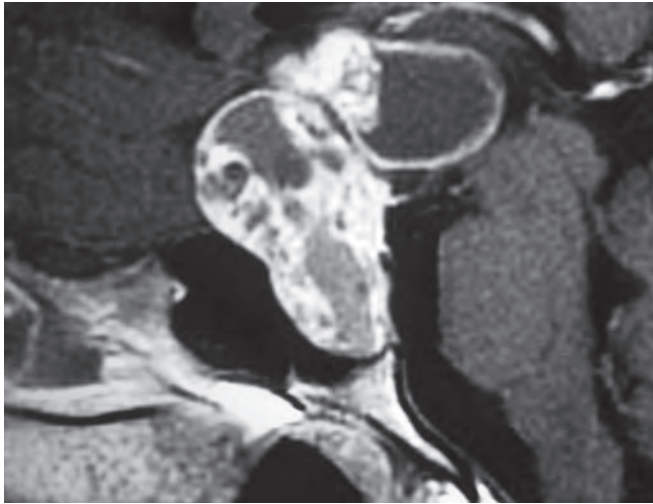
Magnetic resonance imaging showing destruction of the sphenoid sinus by the tumour
